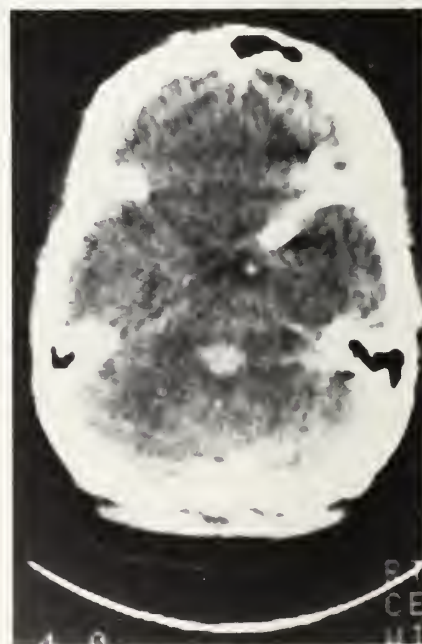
Unenhanced CT of Case 3 showing blood density in the region of the pons.
